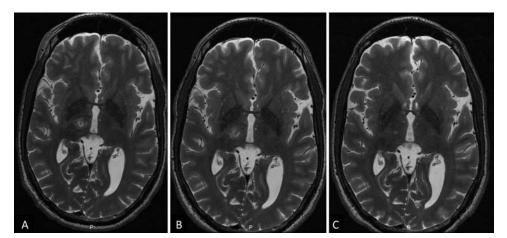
Axial T2-weighted MR images. The slice of the target is presented at 3 time points: 1 day after the procedure (A), 1 week after the procedure (B), and 2 months after the procedure (C). Lesion size and surrounding edema slightly increased on the 1-week postprocedural scan. On the 2-month postprocedural scan, all lesions had decreased in size and the edema surrounding the lesion in the first week had resolved.
